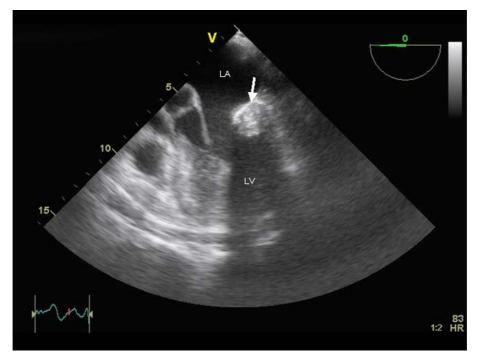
Transesophageal echocardiography showing an inhomogeneous echodense mass (3×2 cm) attached to the posterior mitral annulus. LA, left atrium; LV, left ventricle.
